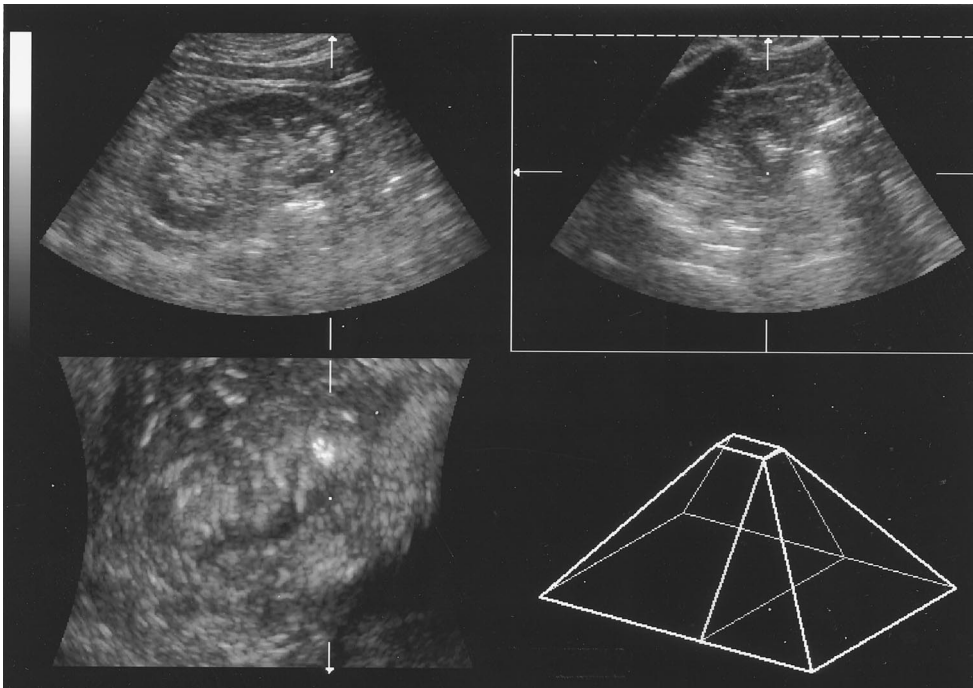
Monitor view of 3D ultrasound: three orthogonal planes of the kidney are displayed simultaneously. Note: dot indicates the same position in the x, y, and z-planes.
